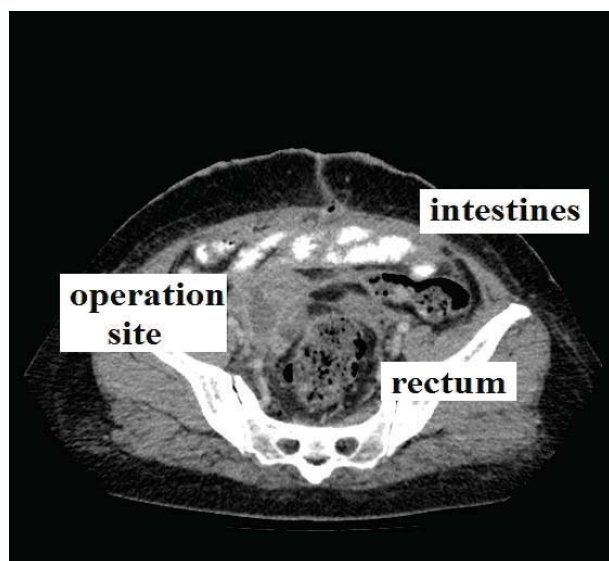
Postoperative computed tomography (CT) scan of the operation site.
